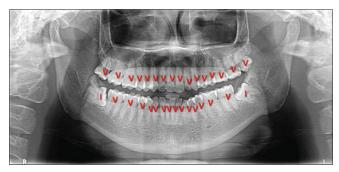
Panoramic radiograph with suitable annotations (commonly observed dental pattern)
